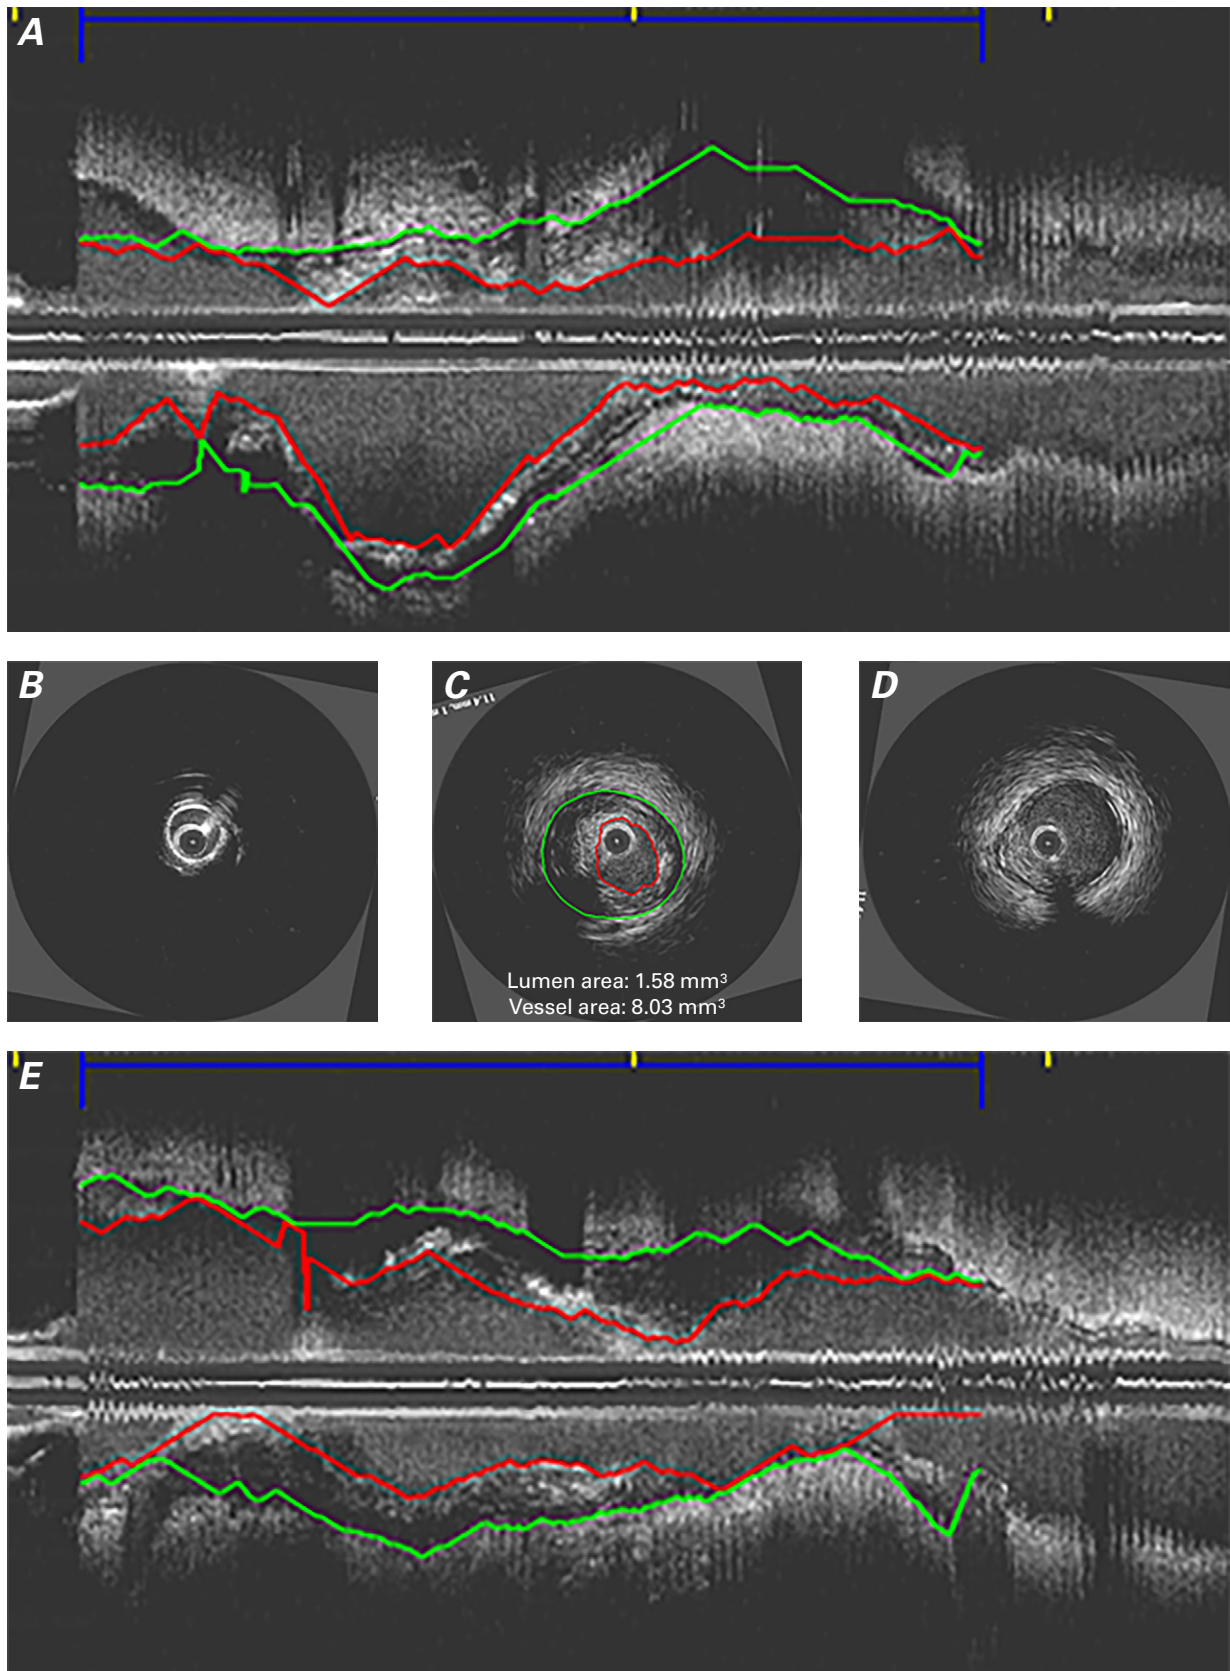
We measured segment plaque volume (indicated by red lines) with use of intravascular ultrasound A) along the length of a left circumflex coronary artery and obtained cross-sectional views of the B) proximal, C) target, and D) distal segments. In C), the luminal area of plaque is 1.58 mm² (vessel area, 8.03 mm²). E) Longitudinal image shows the vessel at a 90° angle.
